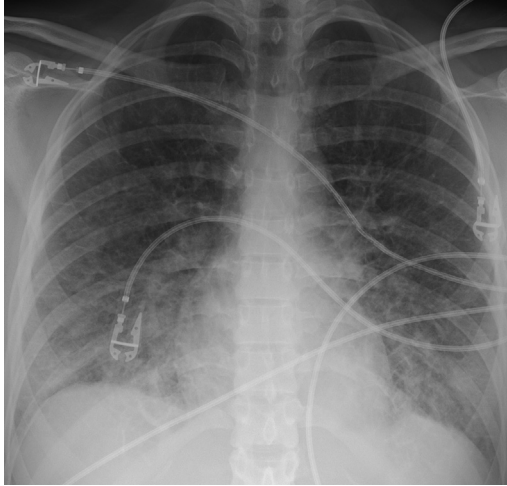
Linear reticular pattern of early hantavirus in a 26-year-old woman. Frontal chest radiograph demonstrates fine reticular and hazy opacities with lower lung predominance.
